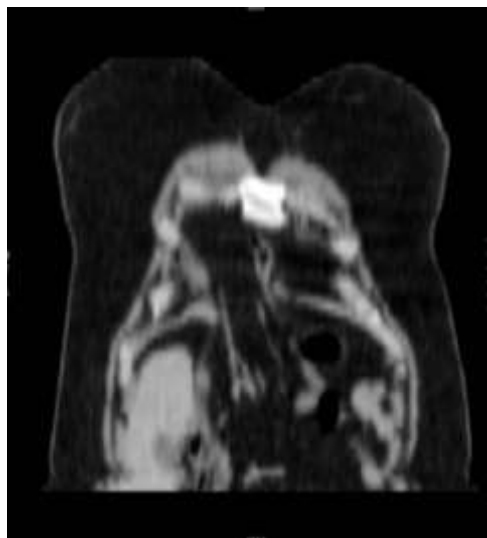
CT showed scans in coronal reconstruction-Morgagni hernia involves the front part of the diaphragm
